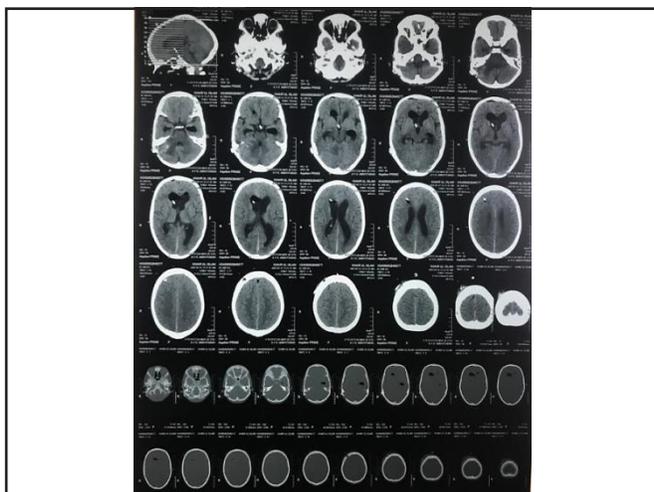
CT brain with the improvement of hydrocephalus after post-op and in situ VP shunt.
